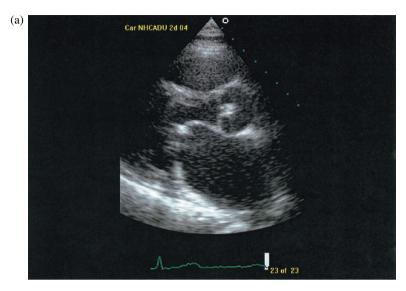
a) Parasternal long axis view of a patient with mitral stenosis showing characteristically doming of the anterior leaflet and thickening of the leaflets, particularly at the tips. b) Parasternal short axis view of severe mitral stenosis showing "fish mouth" appearance of the mitral orifice due to fusion of the commissures.
